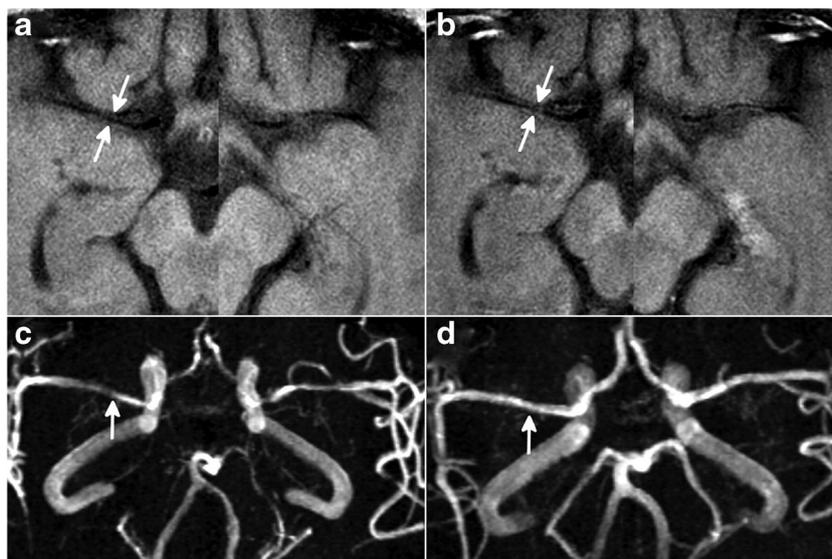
Reversible cerebral vasoconstriction syndrome. Reprinted with permission from Mandell et al., American Heart Association [63]. “Axial T1-weighted vessel wall MRI pre-gadolinium (a) and post-gadolinium (b) at presentation demonstrates arterial wall thickening (arrows) but has absent/minimal arterial wall enhancement. Note the slice positioning is different for the right and left middle cerebral artery images. MR angiography at presentation (c) shows segmental narrowing of the anterior, middle (arrow), and posterior cerebral arteries bilaterally. Three-month follow-up angiogram (d) shows resolution of arterial narrowing.”
